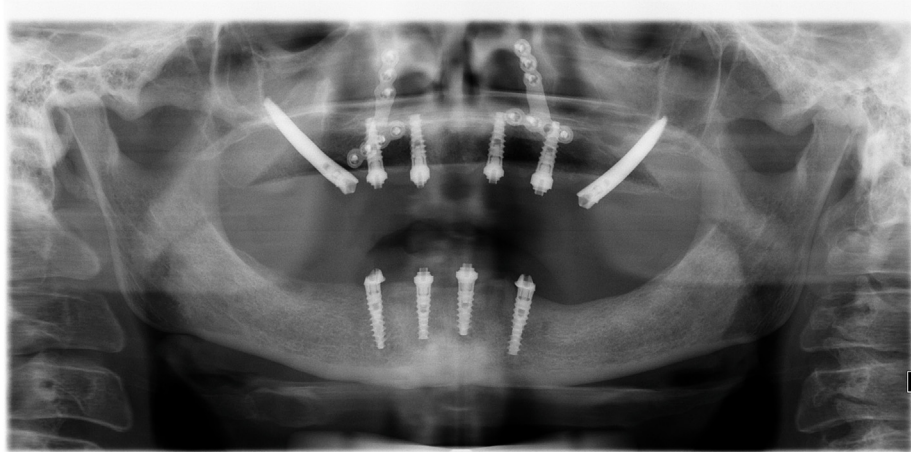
Postoperative panoramic X-ray of the patient.
